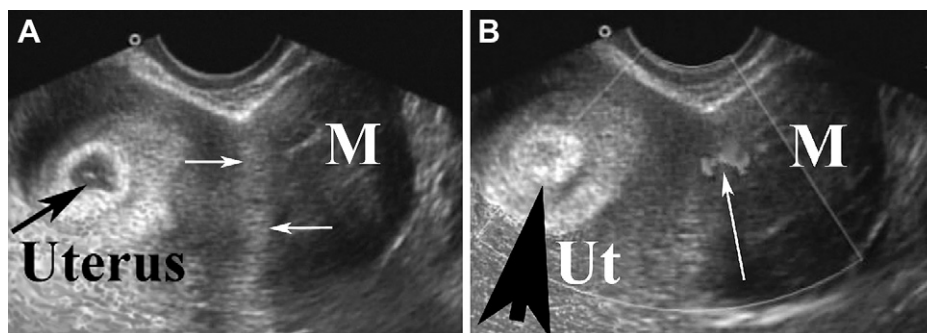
A pregnant woman, at 6 weeks' gestation, presented with a CA 125 level of 1007 U/mL and a left pelvic mass. (A) Transverse view during transvaginal sonography shows an intrauterine gestation (black arrow) and a blurred interface (white arrows) between the mass (M) and the uterus. (B) On color mapping, identification of a connecting vessel (white arrow) between the mass (M) and the uterus (Ut), containing a gestational sac (black arrow), helps make a diagnosis of subserosal myoma.
